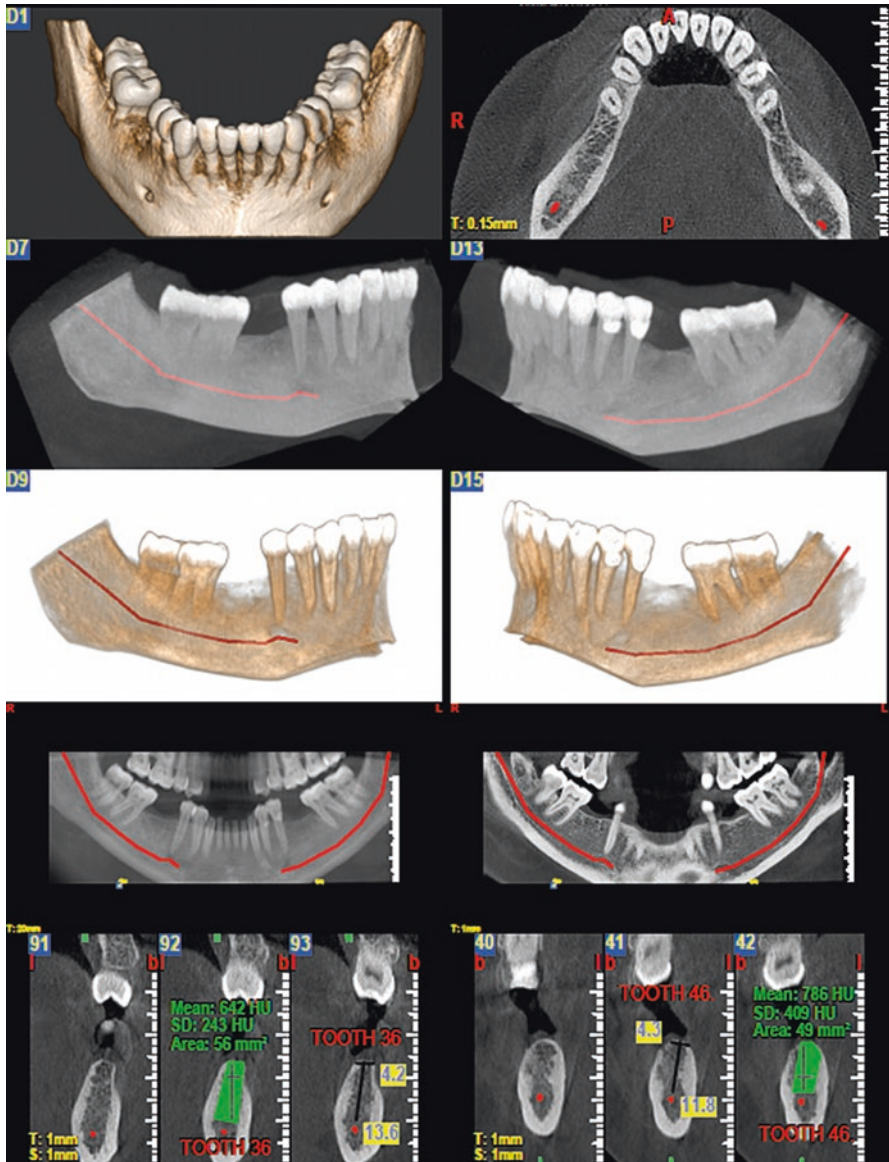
Cone Beam Computed Tomography (CBCT) image with 3-D reconstruction
